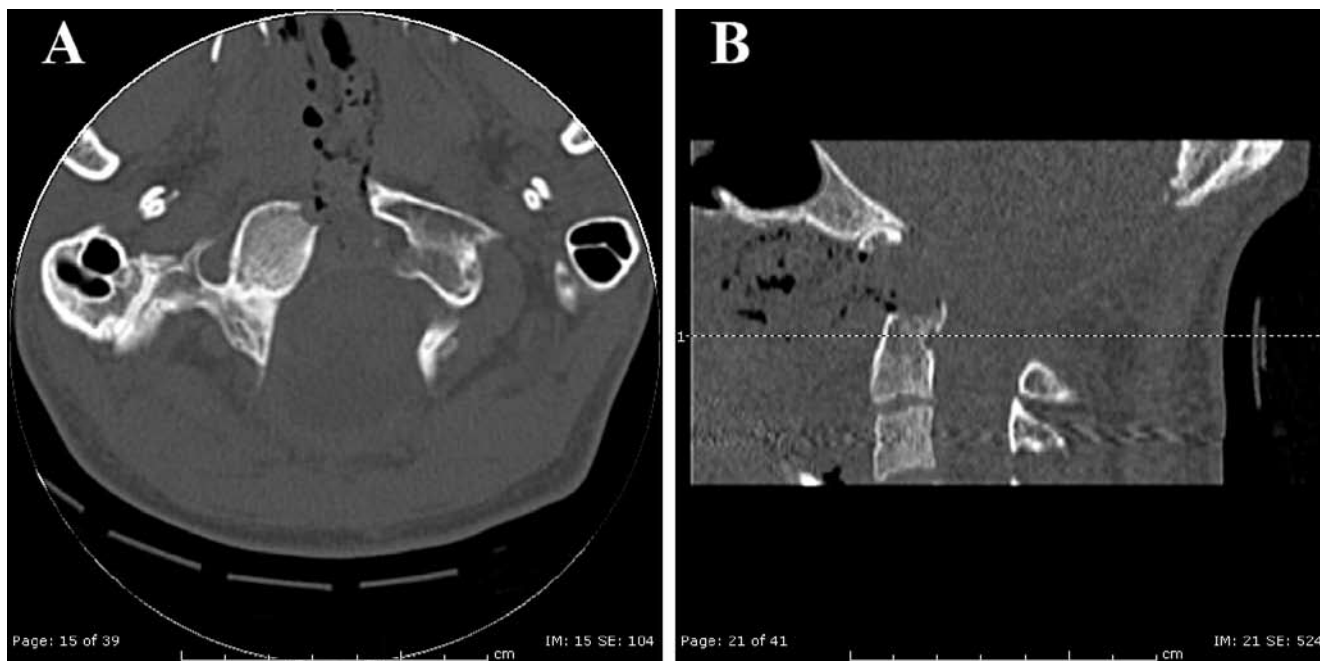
A) Axial CT scan showing resection of the anterior arch of C1 and, at the back, removal of the odontoid process. B) Sagittal CT scan demonstrating the results of the trans-nasal endoscopic resection of the odontoid process. The brainstem at the level of the cervicomedullary junction is decompressed.
